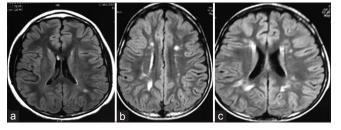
Images of T2-weighted MRI (brain) for three children with acute lymphoblastic leukemia who showed abnormalities. (a) Grade I: 13-year-old female. (b) Grade II: 8-year-old male. (c) Grade II: 6-year-old male
